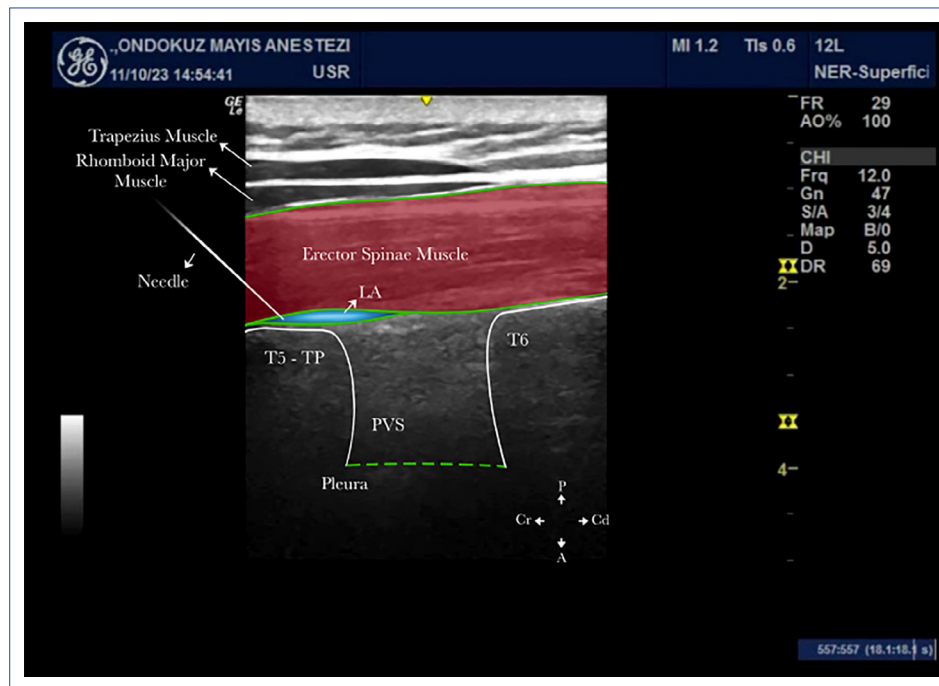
The sonoanatomy for the ESPB. US-guided ESPB, the relevant technique, is depicted in an ultrasound image.
